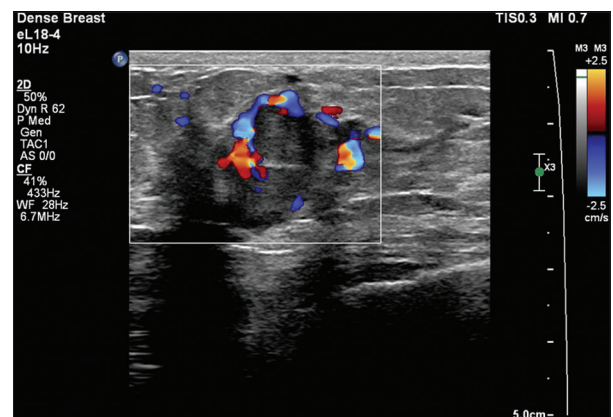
Lesion in the retroareolar region with internal and peripheral vascularity on color Doppler
